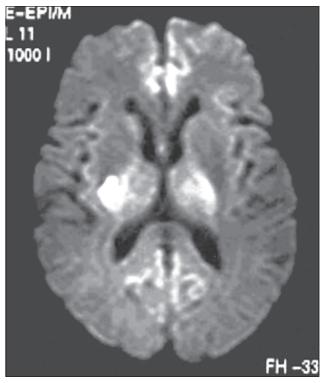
Diffusion-weighted magnetic resonance imaging shows a small subcortical infarct at the right putamen
